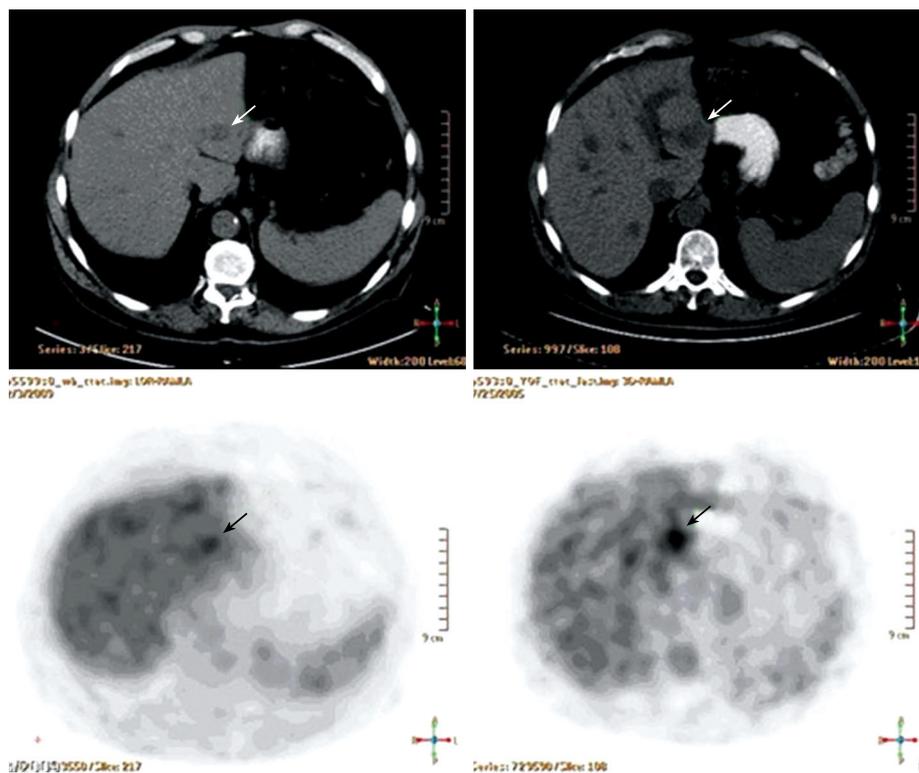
Axial fused PET-CT scans of the upper abdomen before (Right-2005) and after (Left-2009) treatment. Right- An FDG-avid lesion is seen in the left lobe of the liver (arrow). Left-The lesion is smaller with decreased intensity of FDG uptake (arrow).
